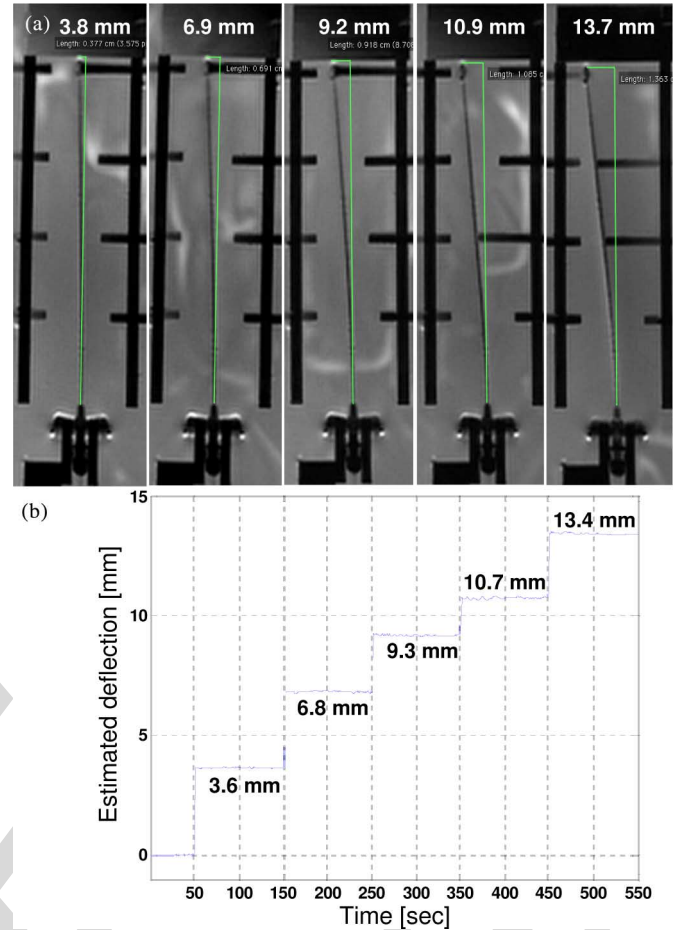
(a) MRI-scanned images with different deflections. The deflection relative to MR images were found using a measurement tool in OsiriX [35] software for viewing medical DICOM images. (b) Estimated needle deflections using FBG sensors.
